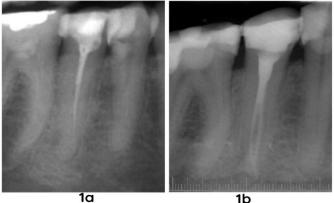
Retreatment of the right mandibular second premolar tooth *a) Initial film showing incomplete root canal treatment and periapical lesion of the right mandibular second premolar tooth. b) Final film taken after treatment of two roots and two canals
